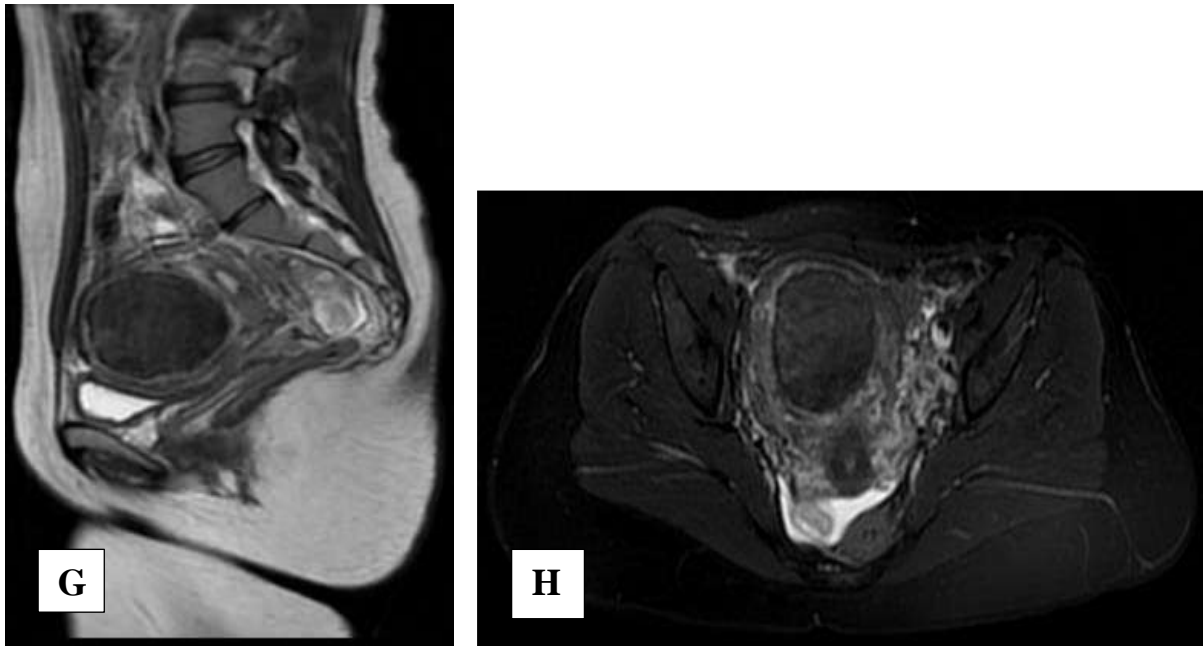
(A&B) : MRI Sagittal T2WI (A) and Axial T2WI fatsat (B) shows large intramural uterine measuring 8.2x7.5x7.2 cm in three dimensions (of volume about 218 mm<sup>3</sup>)
